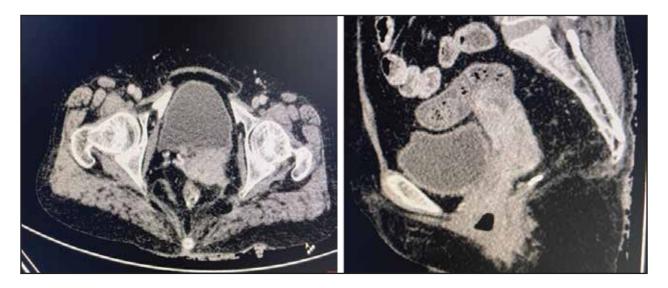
CT images of clinical stage IVA cervical carcinoma. Axial and Sagittal post-contrast images show a heterogeneous enhancing hypodense mass extending to the fundus with infiltration of the posterior wall of bladder.
